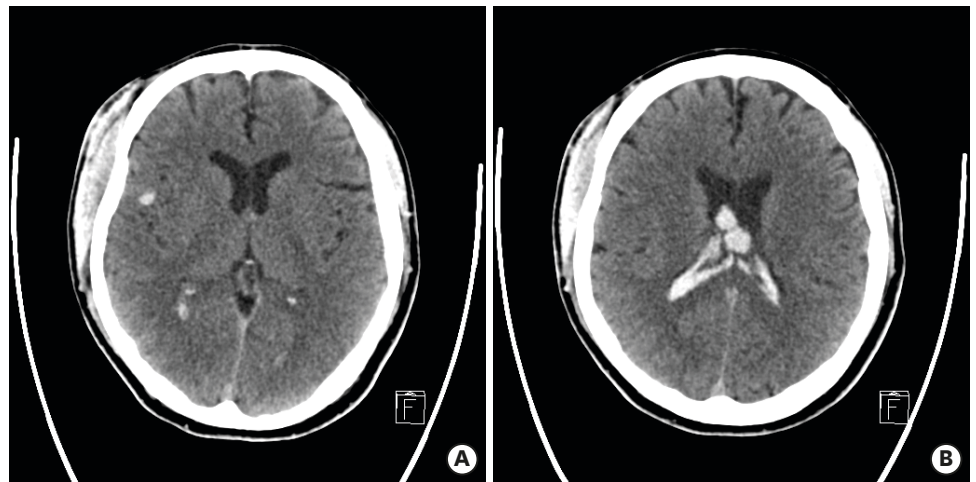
A repeat cranial computed tomography scan obtained 7 hours after the injury reveals increased amount of traumatic intraventricular hemorrhages in bilateral lateral ventricles and a traumatic intracerebral hemorrhage in the right temporal lobe.
